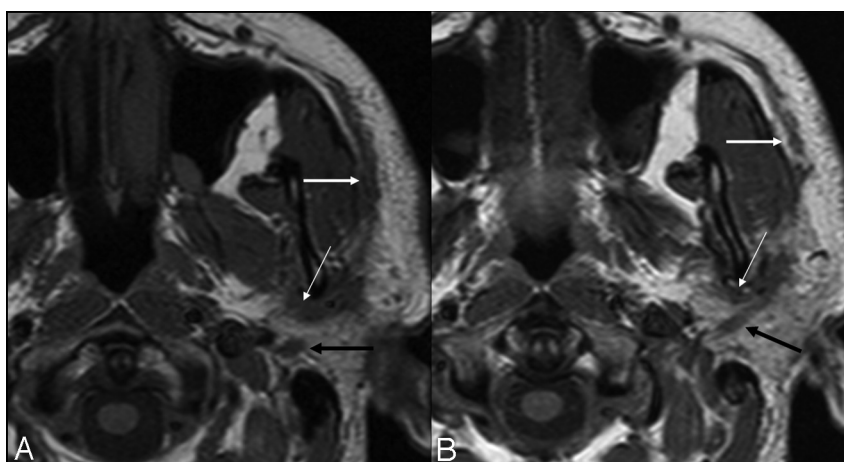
Undifferentiated carcinoma with perineural spread in a 43-year-old male patient. *A*, T1-weighted image shows perineural spread along the auriculotemporal (thin white arrow) branch of trigeminal nerve VIII, the facial nerve (black arrow), and the superficial branch of the facial nerve (thick white arrow). *B*, T1-weighted image of the same patient, a caudal view of image *A*. Note the longitudinal spread along the auriculotemporal (thin white arrow) and facial nerves: backward spread (black arrow) toward the stylomastoid foramen and forward spread along the superficial branch (thick white arrow).
